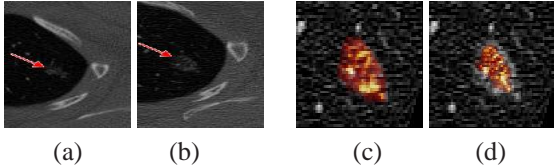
Demonstration of importance of using rigid transformation to align same tumor in serial lung CT data. (a) A small tumor detected during the initial CT scan. (b) A larger tumor detected during a follow-up CT scan. (c) The overlapping result of a non-rigidly aligned small tumor and the large tumor. (d) The overlapping result of the rigidly aligned small tumor and the large tumor.
